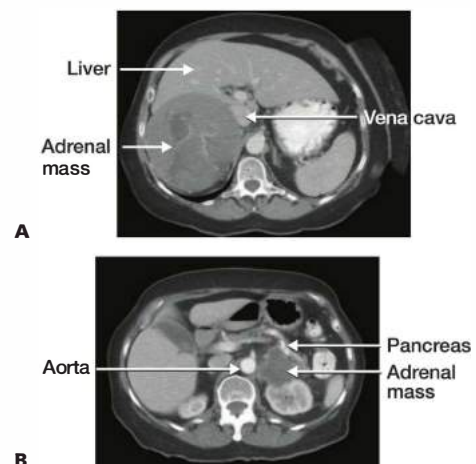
• A. CT scan showing large heterogeneous right adrenal mass concerning for adrenocortical carcinoma. B. CT scan showing a large left adrenal mass.
